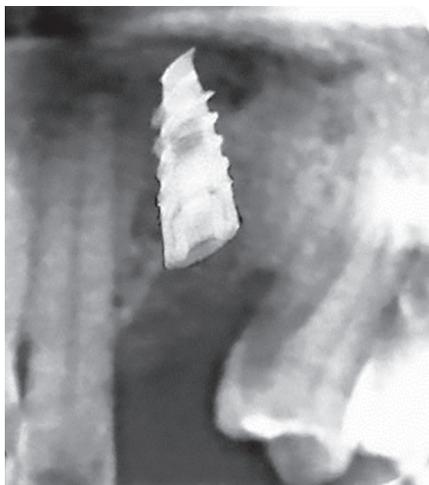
Postimplant radiograph
